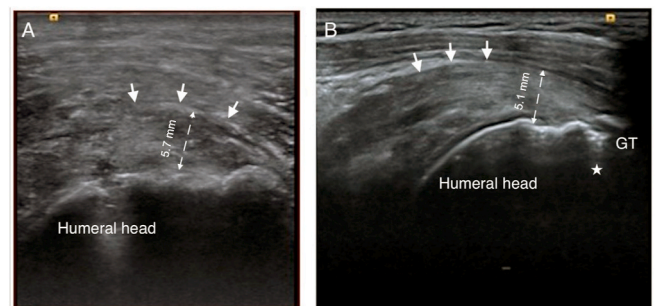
Ultrasound evaluation at 1 month and 3 months after surgery. Picture A on the left is 5.7mm thick at 1 month, picture B on the right is 5.1mm thick.
